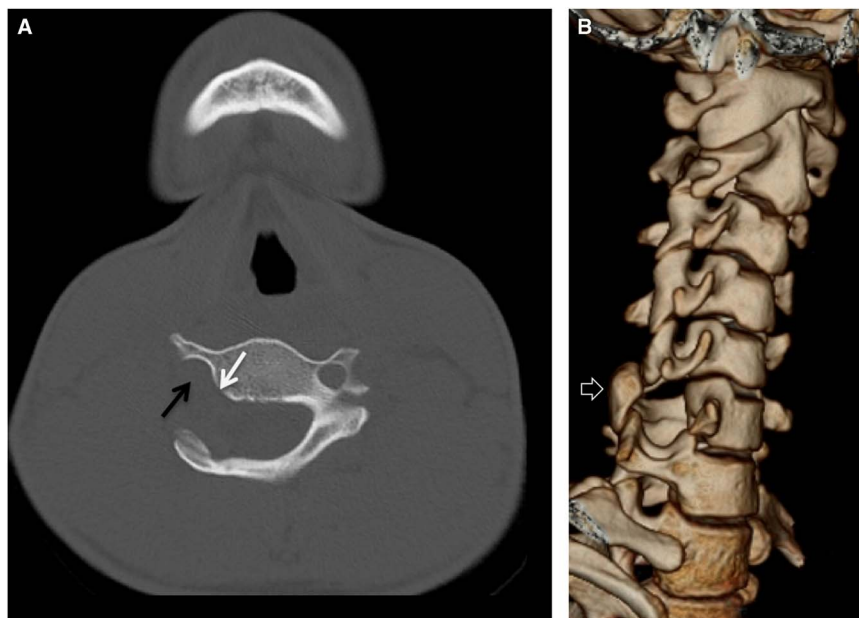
CT scan. (A) Axial image adjusted in bone window shows the absent right pedicle (white arrow) and dysplasia of the ipsilateral transverse process (black arrow). (B) 3D volume rendering reformatted image demonstrates the dorsal displacement of the articular pillar and reversal facet articulation (open arrow) with hyperplasia of the superior and hypoplasia of the inferior articular facets.
